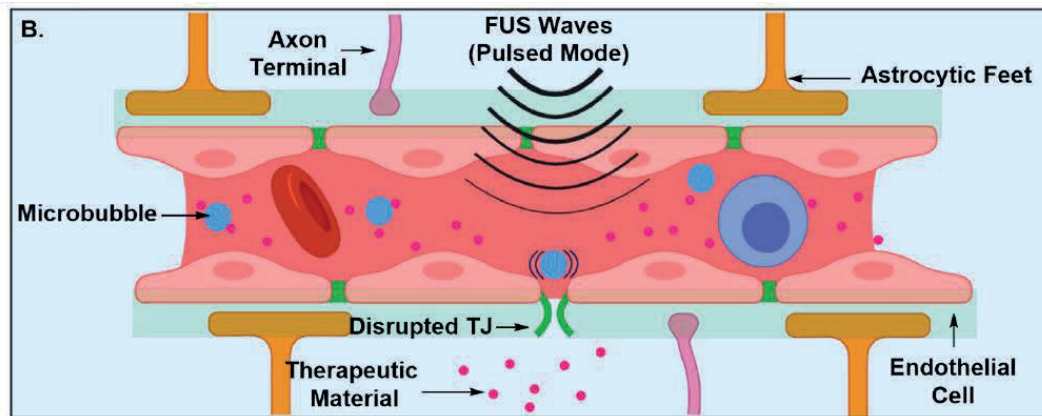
Scheme of the microbubble-assisted focused-ultrasound technique used for disrupting the BBB. Modified from Abdul *et al*(22).
